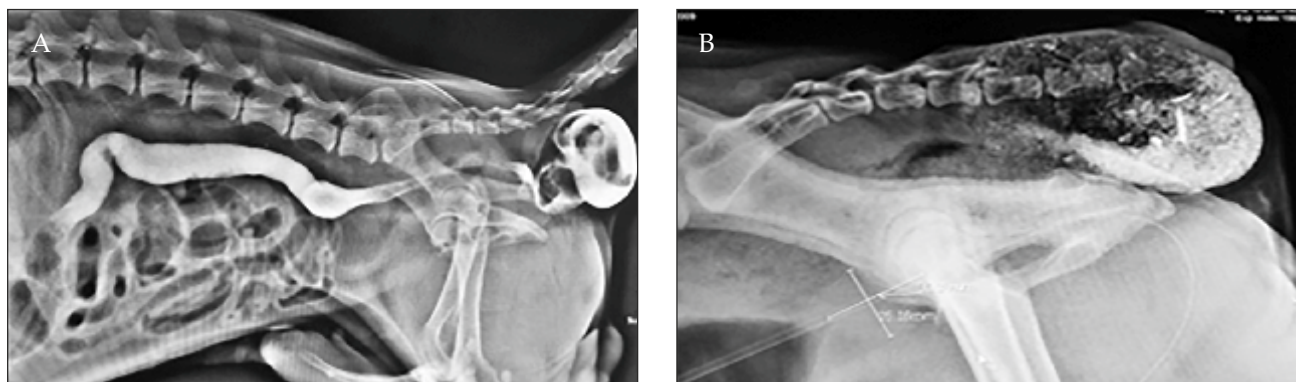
(A) Perineal hernia with rectal sacculcation; (B) Plain radiograph showing elevated tail head due to the rectal sacculcation.
